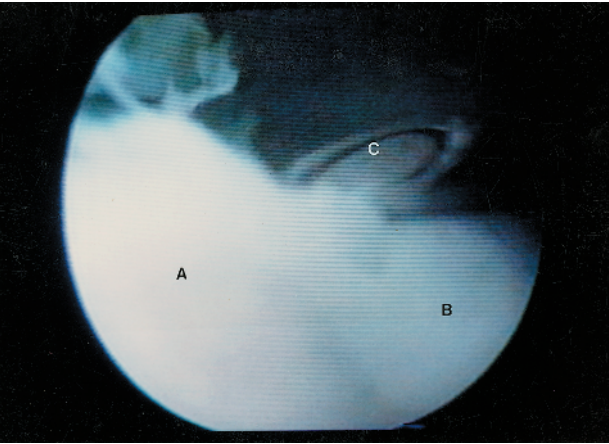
Video-arthroscopic view of the lesion seen in Figure 7.64. The lesion appeared intact on radiography but was not intact at arthroscopy because the articular cartilage over the lesion had a different texture and color. The lesion was easily lifted with a needle. A, separated osteochondritis lesion; B, dome of the talus; C, tip of the hypodermic needle.
